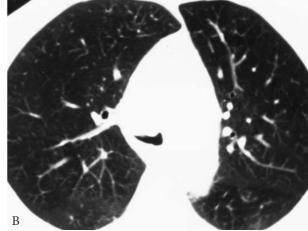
Tracheobronchial tuberculosis with lymphadenitis. Computed tomography scan at the level of the carina with soft tissue windows (A) and lung windows (B) reveals an enlarged necrotic low attenuation lower paratracheal lymph node that contains calcification (A). There is extension of the granulomatous process narrowing the right main bronchus (B).
